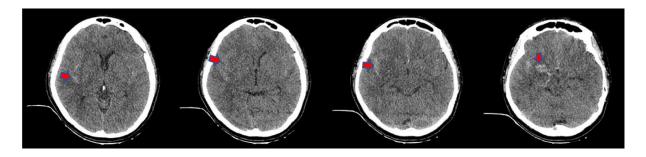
CT scan results dominant SAH on the right side.
